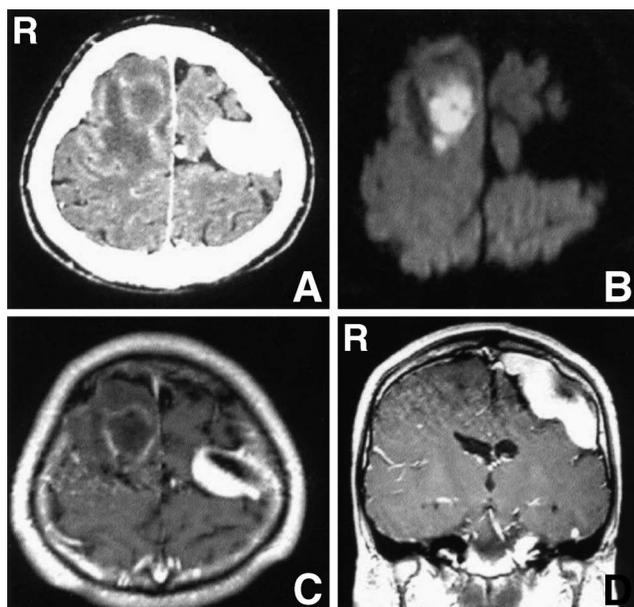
A: Computed tomography scan of the patient's head showing a right frontal ring-like enhanced lesion with surrounding low density area and a highly enhanced mass lesion in the left central region. B: Axial diffusion-weighted magnetic resonance (MR) image showing multiple hyperintense lesions, with the largest in the right frontal lobe, indicating brain abscesses. C: Axial T₁-weighted MR image with gadolinium showing a ring-like enhanced lesion in the right frontal lobe and a hyperintense enhanced mass lesion in the left central region. D: Coronal T₁-weighted MR image with gadolinium showing a large extra-axial mass lesion with strong enhancement and partial hypointense area.
